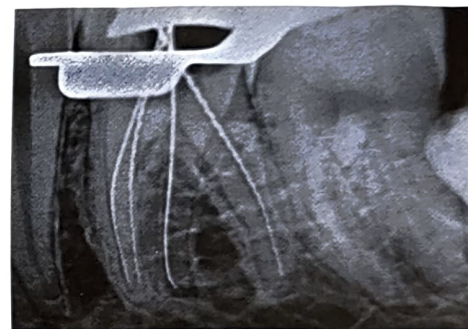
CASE II: Working length radiograph
